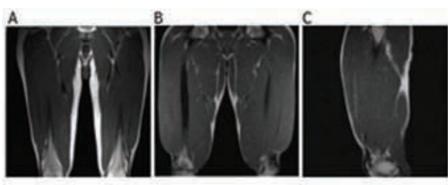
Coronal (A, B) and sagittal (C) magnetic resonance images (MRI) of the thigh of a normally active subject (A) and a body builder (B, C) highlight dramatic increase of skeletal muscle mass following long term heavy resistance training (modified from D'Antona *et al.* 2006).
